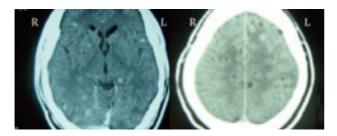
Computed tomography of the head shows multiple cysts with calcifications.
